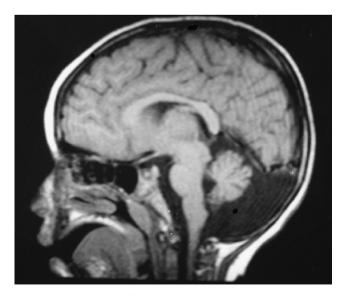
Brain MRI of patient 1, at the age of 2 years: T1 midsagittal image demonstrates enlarged cisterna magna with atrophic vermis. The pons is preserved.
